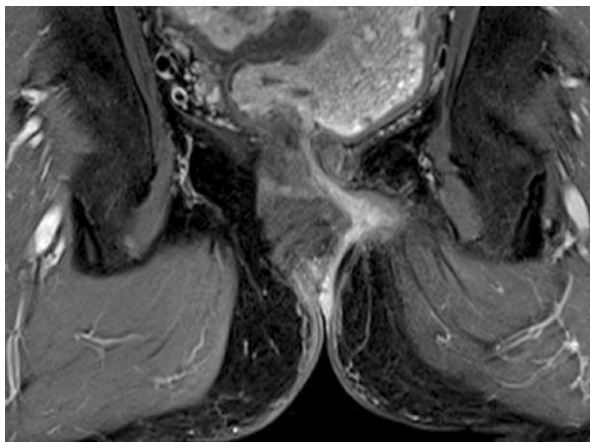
Axial serial MR images of transsphincteric perianal fistula with intersphincteric space abscess. Note the fistula track traverses at 5 o'clock
